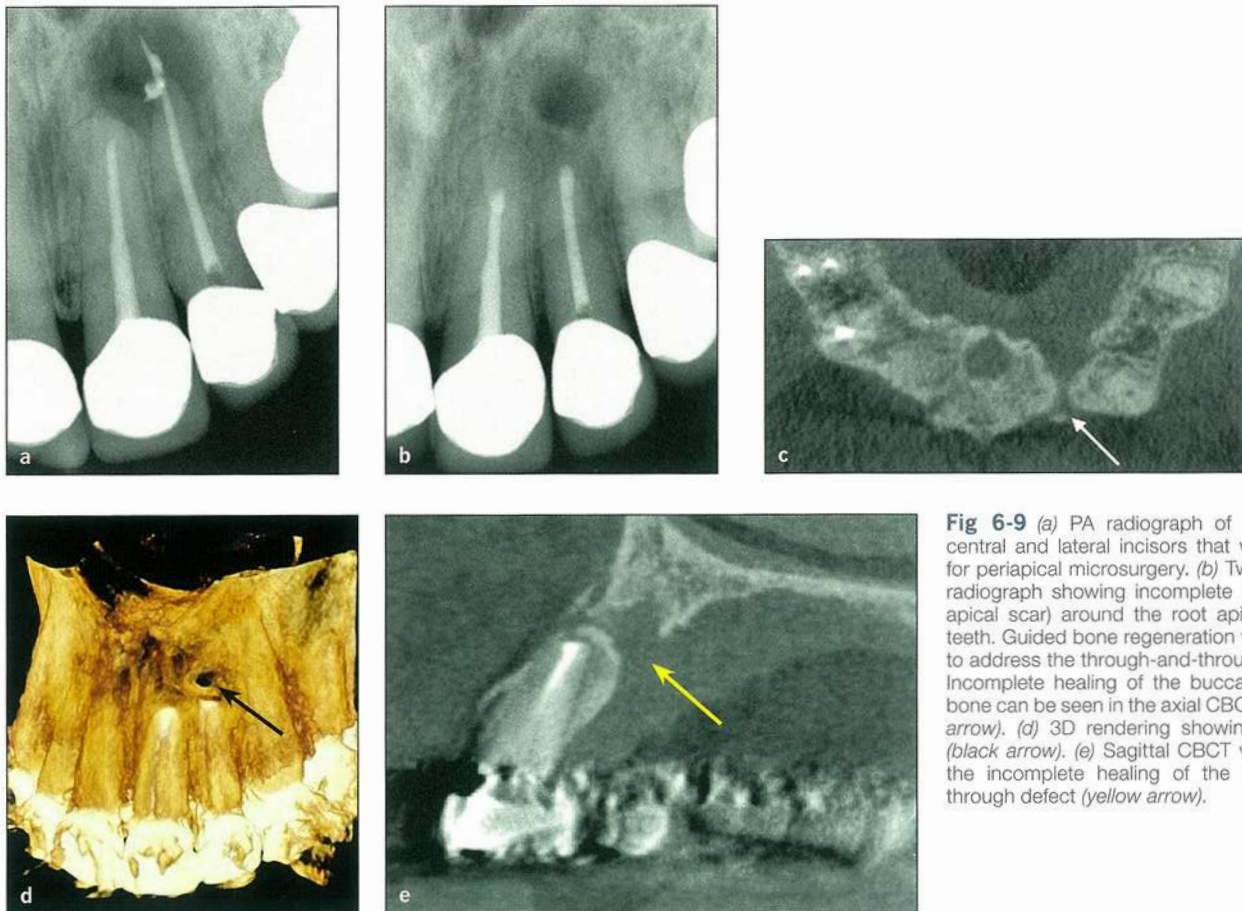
(a) PA radiograph of maxillary left central and lateral incisors that were referred for periapical microsurgery. (b) Two-year recall radiograph showing incomplete healing (periapical scar) around the root apices of these teeth. Guided bone regeneration was not used to address the through-and-through defect. (c) Incomplete healing of the buccal and palatal bone can be seen in the axial CBCT view (white arrow). (d) 3D rendering showing the defect (black arrow). (e) Sagittal CBCT view showing the incomplete healing of the through-and-through defect (yellow arrow).
